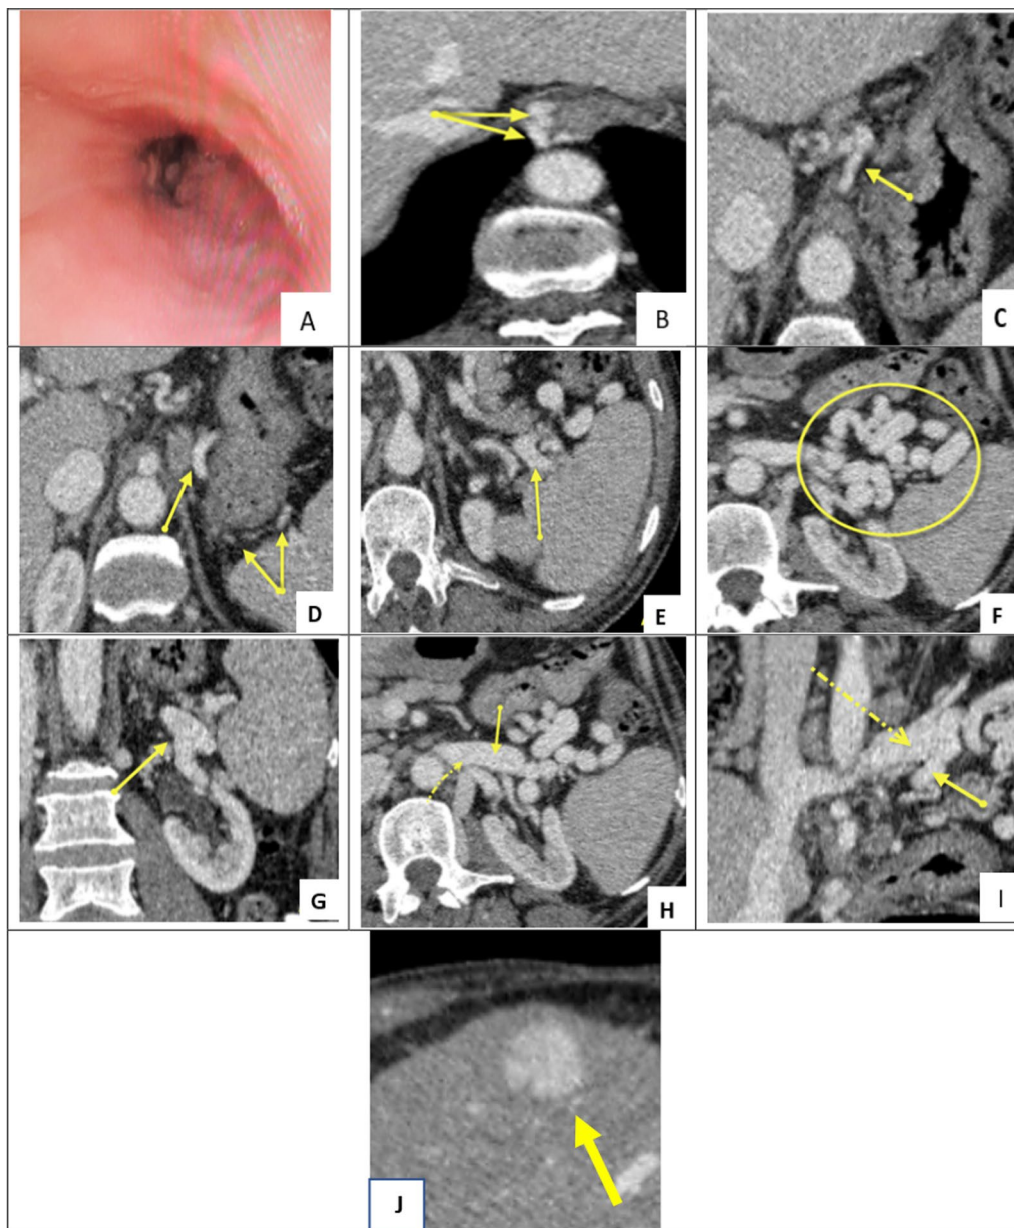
A 69-year-old male patient performed Upper GI endoscopy and triphasic MDCT scanning for chronic liver disease and HFL to identify varices and HFL scanning. A Upper GI endoscopy shows no esophageal varices. Axial CT shows; B multiple paraesophageal varices (solid arrows), C left gastric (coronary) varix (solid arrow), D retrogastric (adventitial) varices (solid arrows), E, F normal splenic vein diameter (solid arrow), dilated and tortuous lienorenal shunt (round mark). G Coronal CT shows a lienorenal shunt (solid arrow). H Axial CT of the lienorenal shunt (solid arrow) and the left renal vein (dashed arrow). I Coronal CT shows a gastrosplenic shunt (solid arrow) and the left renal vein (dashed arrow). J Axial CT shows a hepatic focal lesion with rapid enhancement in the arterial phase
